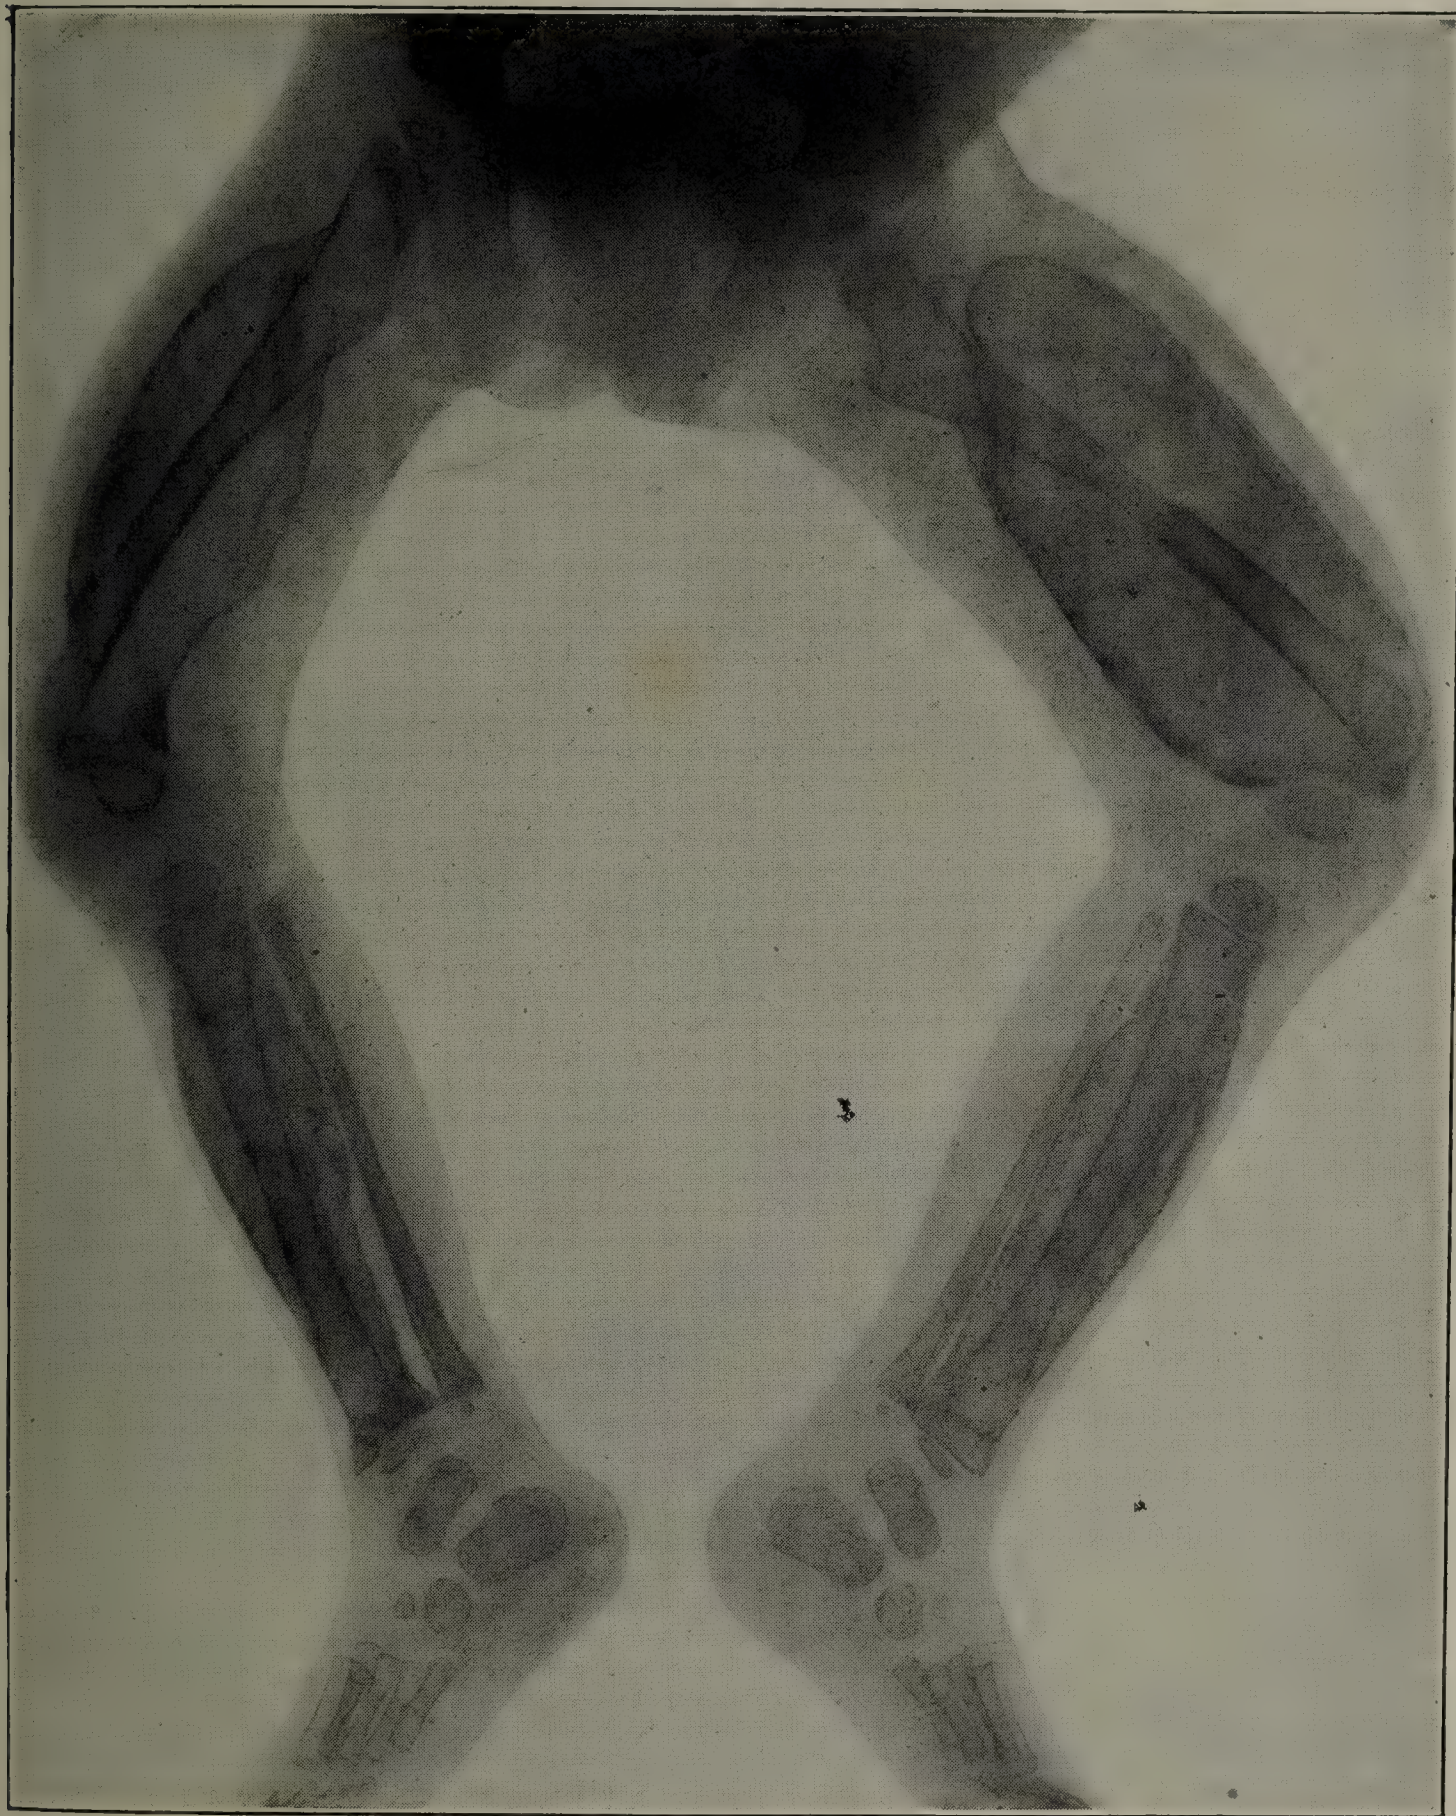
ROENTGENOGRAM IN SEVERE SCURVY, IN HEALING STAGE.
